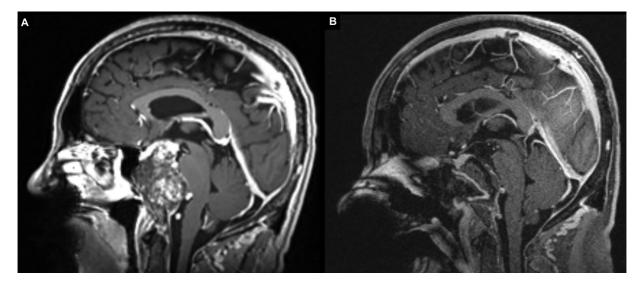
Preoperative magnetic resonance imaging (MRI) of clival chordoma (A) and immediate postoperative MRI of subsequent posterior cranial fossa defect (B) reconstructed using a multilayer technique, including an extended nasoseptal flap.
